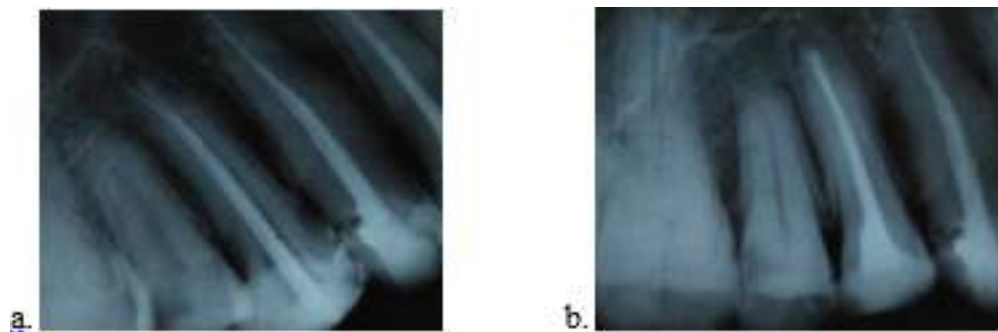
(a).Master cone radiograph of tooth #14. (b). Obturation radiograph of tooth #14
